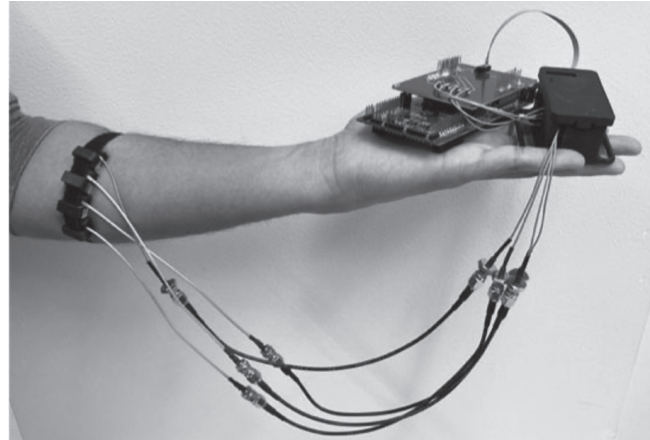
Our wearable ultrasound system can be embedded into an upper-limb prosthesis to extract prosthesis control signals from forearm muscle activity.
